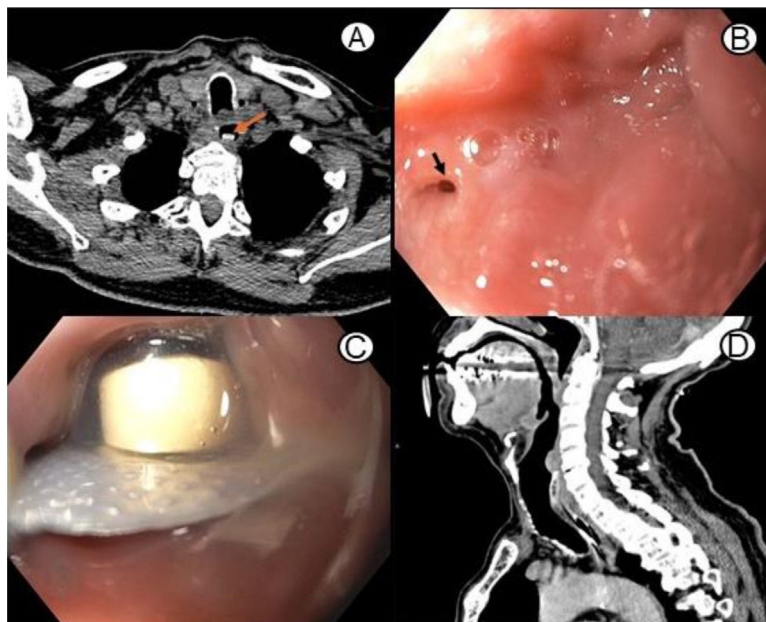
Tomographic and endoscopic findings of a foreign body impacted in the cervical region of the esophagus. A) Axial CT view showing a foreign body (arrow) in the esophageal lumen. B) EGD showing a 3 mm perforation (arrow) on the left side of the hypopharynx. C) EGD showing the tablet and its blister pack in the cervical esophagus. D) Control CT at 5 days after the endoscopic examination, showing no signs of esophageal perforation.
